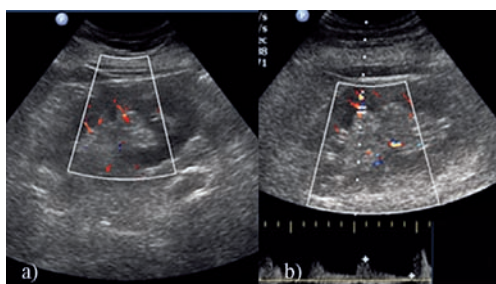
a) Doppler US of the left kidney: hypoechoic areas and poor arterial signal; b) Duplex Doppler US of the left kidney – high resistivity index.
